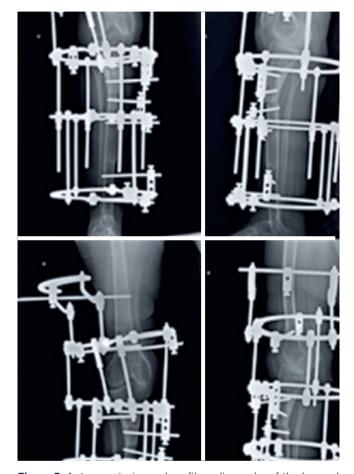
Anteroposterior and profile radiographs of the leg and knee, with the assembly of circular external fixator, including knee and ankle for bone lengthening, with osteotomy in the proximal tibia.
